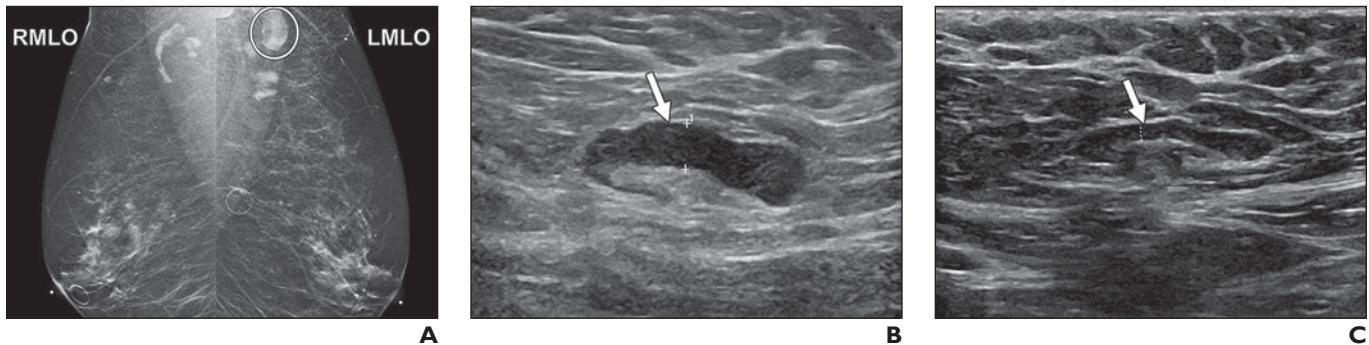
53-year-old woman undergoing screening mammography and breast ultrasound.
